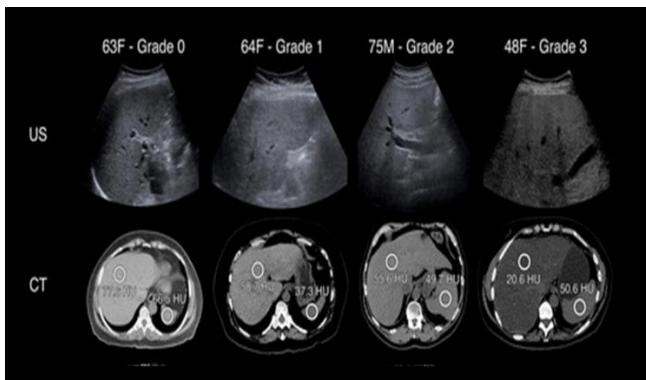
Samples of ultrasound and CT liver images from obtained data.
